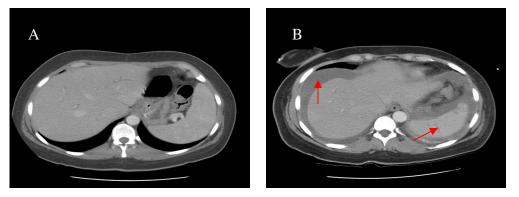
(A) CT scan of the abdomen upon admission without evidence of splenic rupture. (B) Repeat abdominal CT scan two days later revealed free intraperitoneal fluid, hypodensity in the spleen, and capsular changes consistent with splenic rupture (see arrows).
